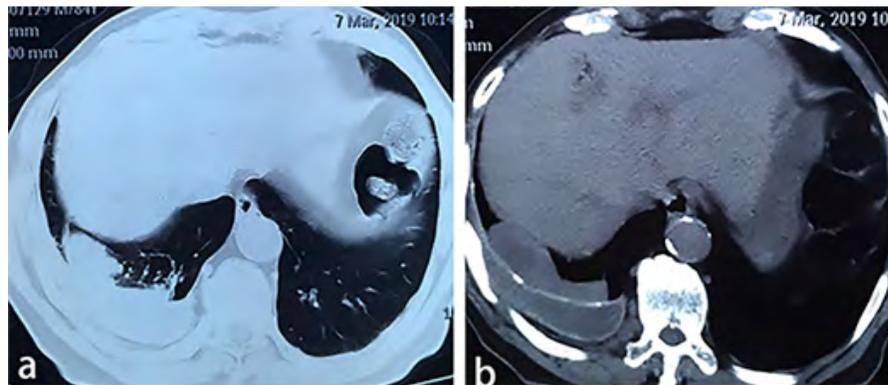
The results of CT examination showed (a) inflammation of the right lower lobe, chronic empyema on the right with subdiaphragmatic infection, fibrosis of the right lung, atherosclerosis, thickening of the left pleura, with (b) rib destruction, and membranous calcification around the lesion.
